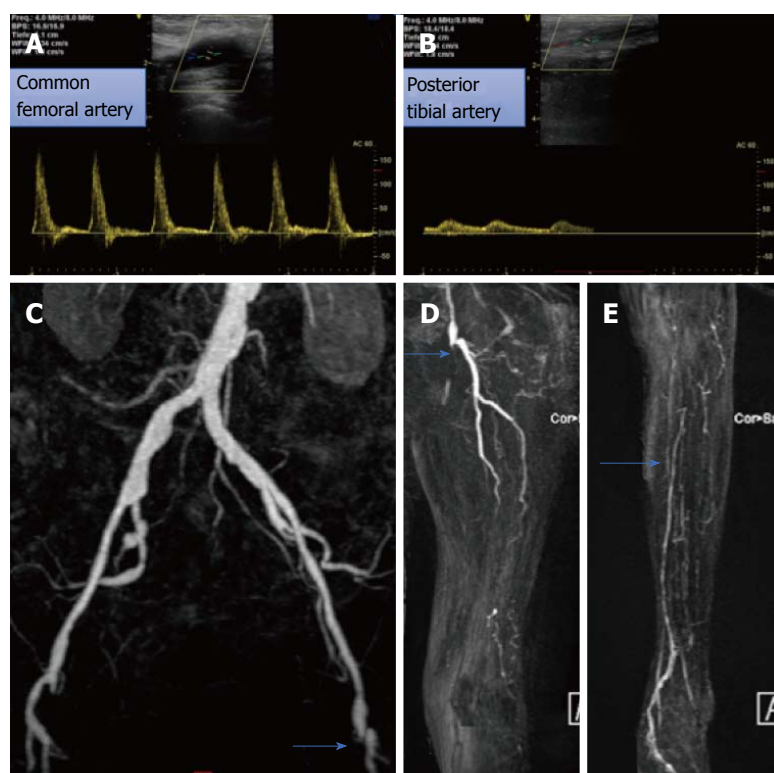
Duplex sonography and magnetic resonance angiography findings. A: Biphasic flow in the left common femoral artery; B: Blunted monophasic flow in the posterior tibial artery due to long occlusive disease; C: Absence of flow limiting stenosis in iliac arteries by magnetic resonance angiography; D: Long total occlusion of the SFA (blue arrow) and of the popliteal artery; E: Collateral filling in the proximal part of the posterior tibial artery (blue arrow). SFA: Superficial femoral artery.
